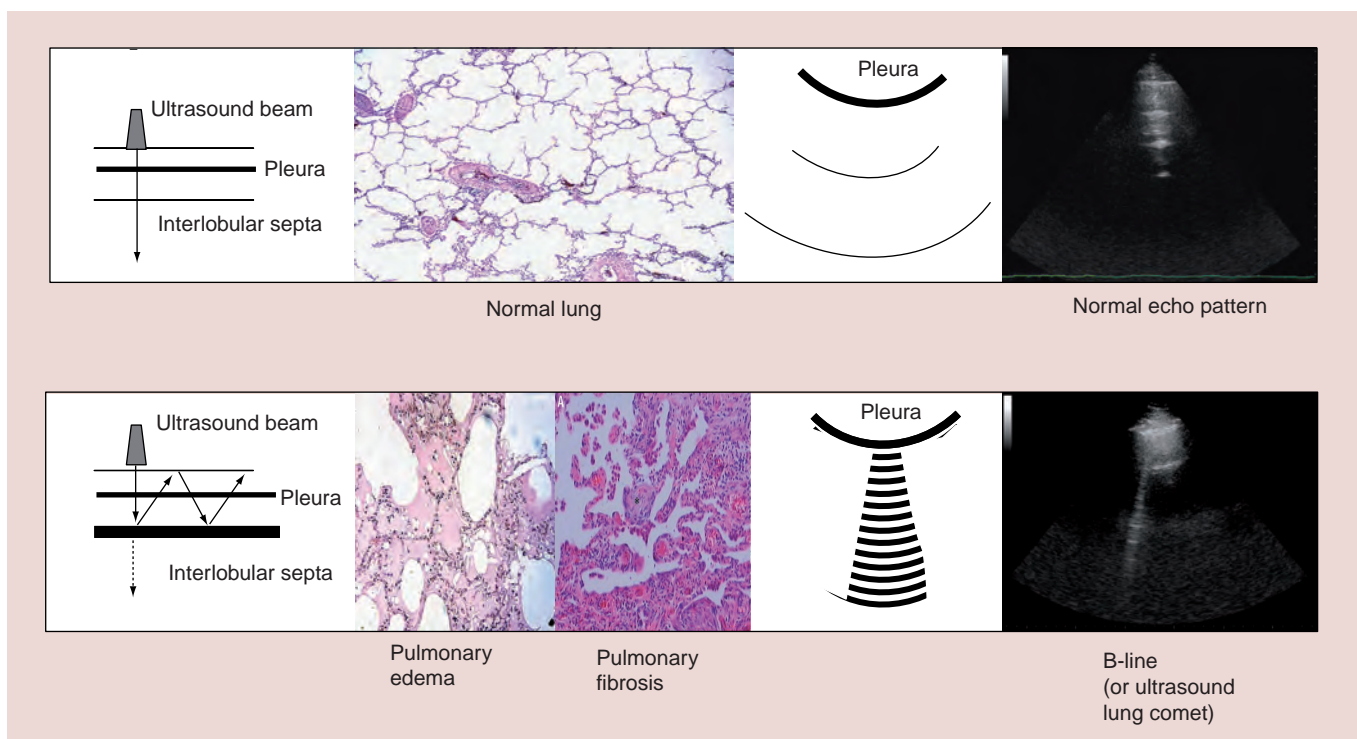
The hypothesized physical and anatomic basis of ultrasound lung comets: reflections of the ultrasound beam by the thickened interlobular septa give rise to the 'comet-tail' artifact.
